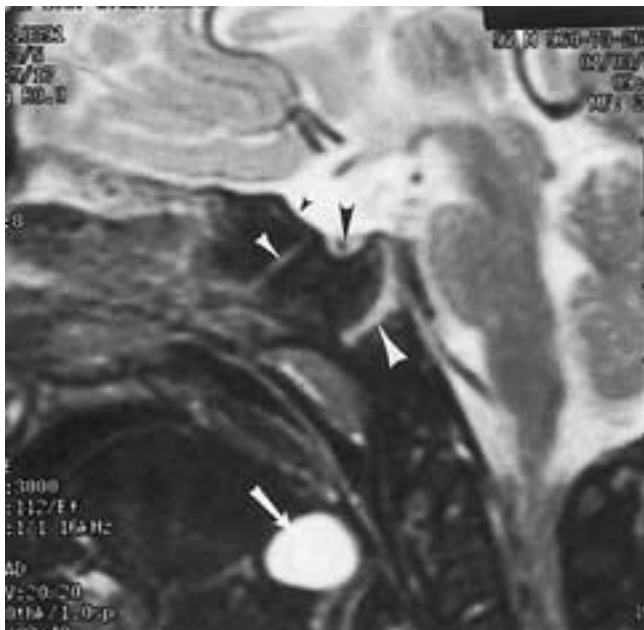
Normal clivus in a child evaluated for thyroglossal duct remnant or cyst. T2-weighted image shows the thyroglossal abnormality in the tongue base (*white arrow*). The synchondrosis (*small white arrowhead*) between the pre- and postsphenoid ossification centers is easily identified, as is the synchondrosis between the sphenoid and occipital bones. *Large black arrowhead*, pituitary fossa; *small black arrowhead*, chiasmatic groove.
